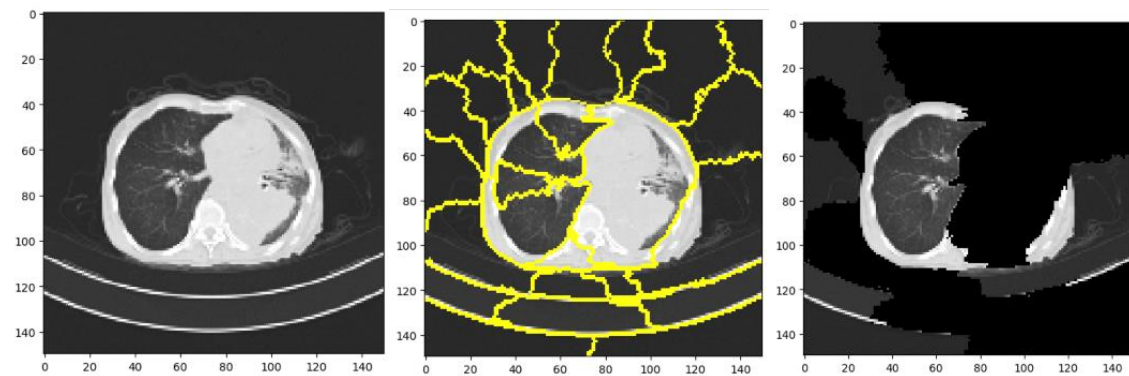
Interpretations generated by LIME for cancerous tissue. The leftmost is sample of cancerous CT images from the test image. The middle one represents super pixels generated from quick-shift segmentation to create perturbations. The rightmost represents the final perturbed image showing the presence of cancerous tissue.
